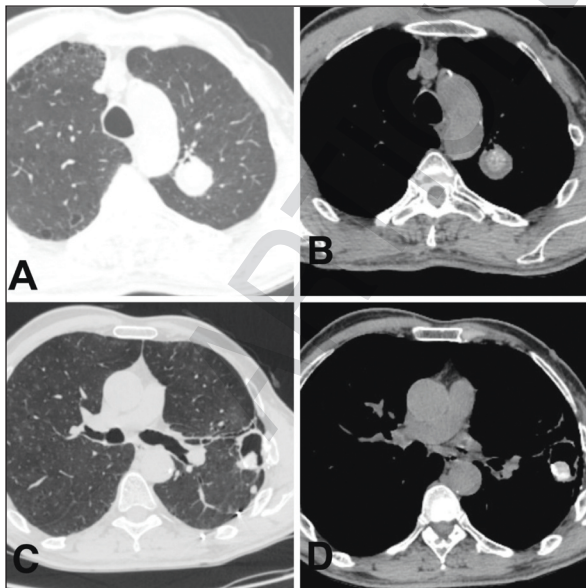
A, B) Thoracic computed tomography scans demonstrating a mass lesion in the apicoposterior segment of the left upper lobe, shown in both parenchymal and mediastinal windows; C, D) Thoracic computed tomography scans revealing a cavitory lesion in the lingular segment of the left upper lobe, visualized through parenchymal and mediastinal windows
